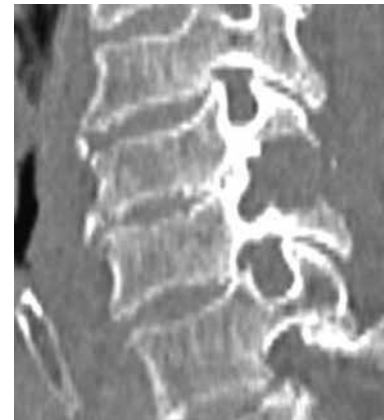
Preoperative CT Scanning in the oblique axial plane (A) and the oblique sagittal plane(B) demonstrating the right side of foraminal stenosis at C5-C6.
